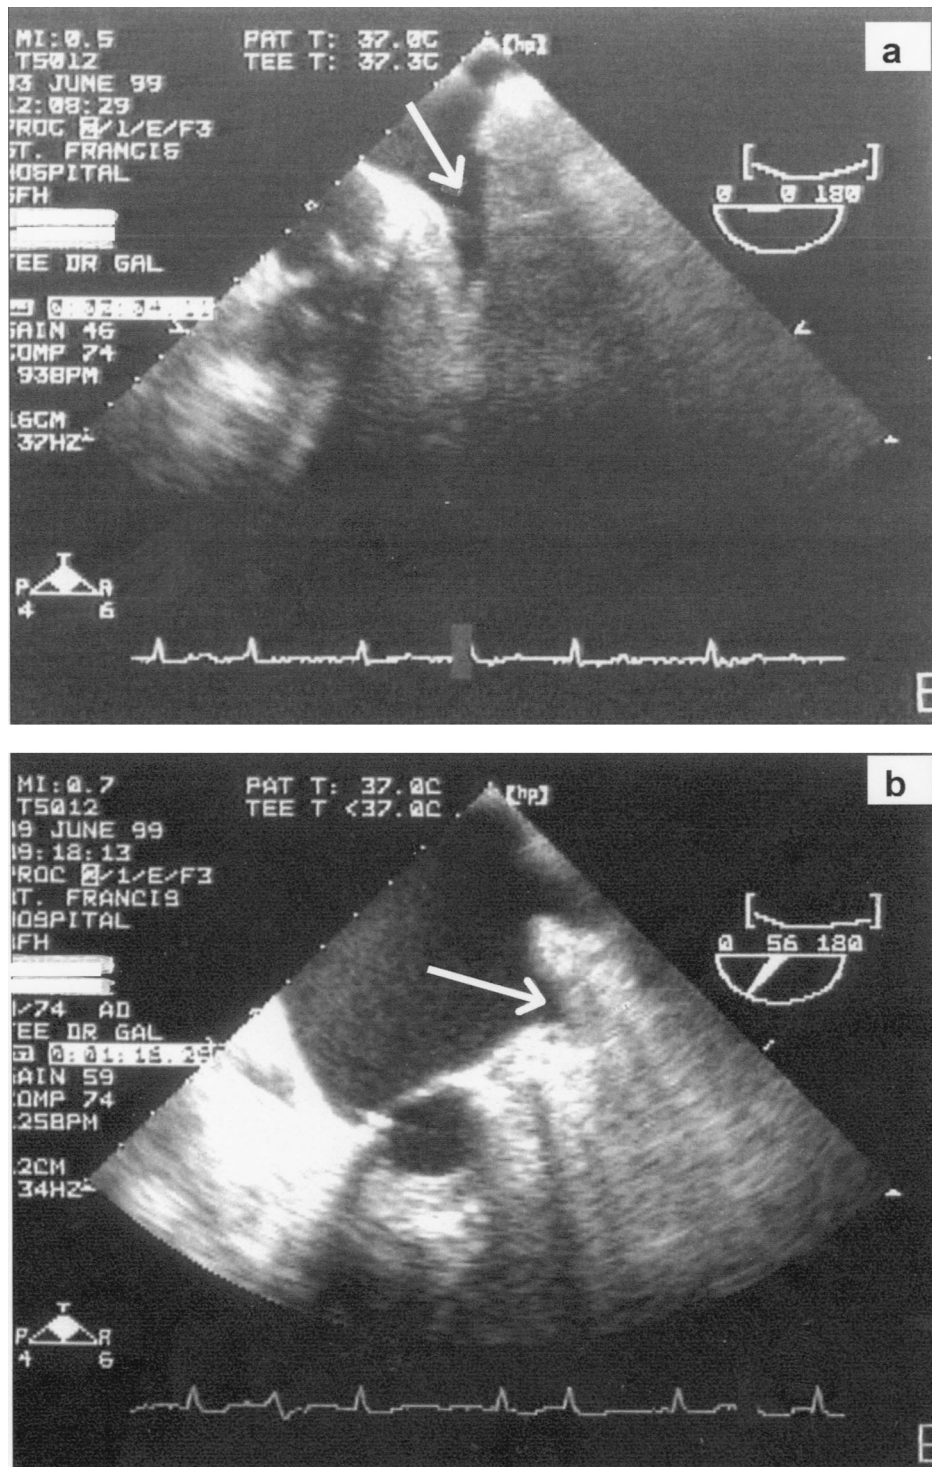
(a) Pre-operative transesophageal echo visualization of an open appendage without clot. (b) Postoperative transesophageal echo showing obliteration of appendage after stapling.
